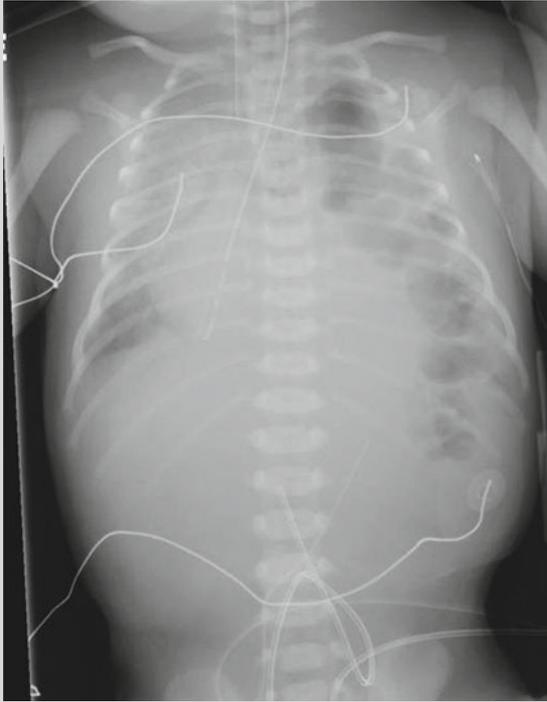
Chest radiograph at 1 h of age demonstrating bowel in left chest and shift of mediastinum to right
